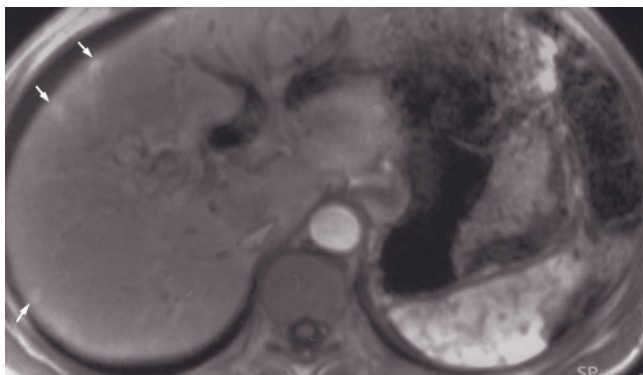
Staging pancreatic cancer—liver metastases. T2-weighted SS-ETSE (*a*), T1-weighted SGE (*b*), T1-weighted fat-suppressed SGE (*c*), immediate postgadolinium T1-weighted SGE (*d*, *e*), and 90-s postgadolinium fat-suppressed SGE (*f*) images. A 4 × 5-cm tumor arises in the pancreatic tail. Note the shape demarcation of normal pancreas (arrow, *c*) proximal to the large pancreatic cancer. There are multiple liver metastases that are mildly hyperintense on T2 (*a*) and mildly low signal on T1, reflecting a low fluid content. Liver metastases are best seen as ring-enhancing lesions on immediate postgadolinium images (*d*, *e*) with ring-enhancing metastases involving both lobes. Pancreatic cancer most commonly metastasizes to the liver.
